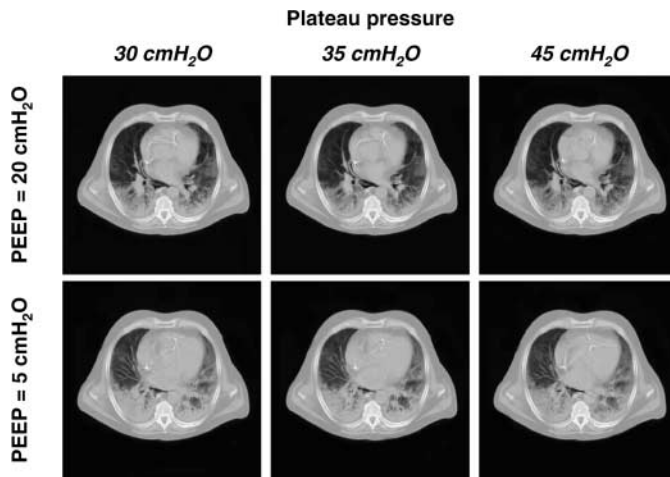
A representative CT scan obtained in one patient at end expiration for each experimental step. At a similar PEEP level, either 5 or 20 cm H₂O, the amount of end-expiratory collapse was dramatically different, depending on whether ventilation was performed at 30, 35, or 45 cm H₂O of plateau pressure.
